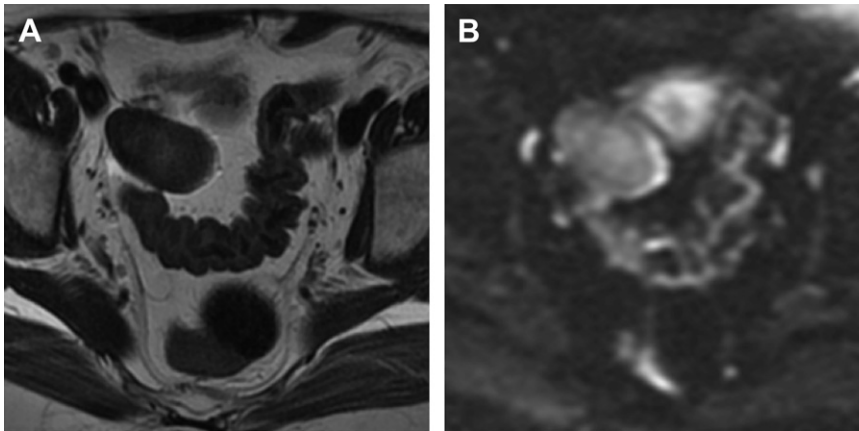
Fibrotecoma. Solid adnexial lesion showing low SI on the T2-weighted and DW images. (A) Axial T2-weighted image. (B) DWI.
